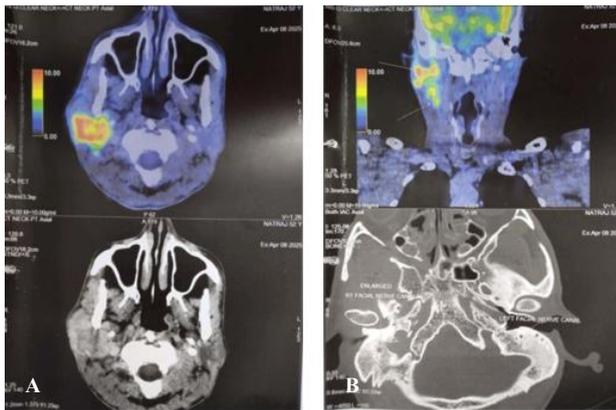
(A and B): PET CT images of the tumour.
